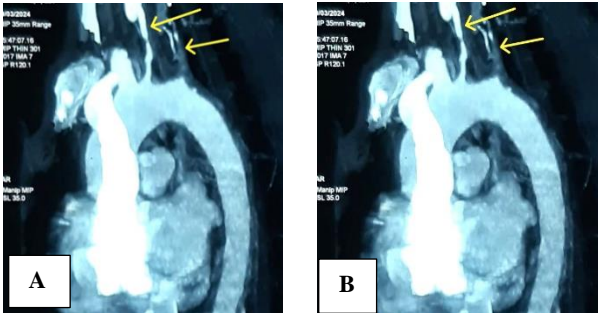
(A and B): CT aortogram findings.
